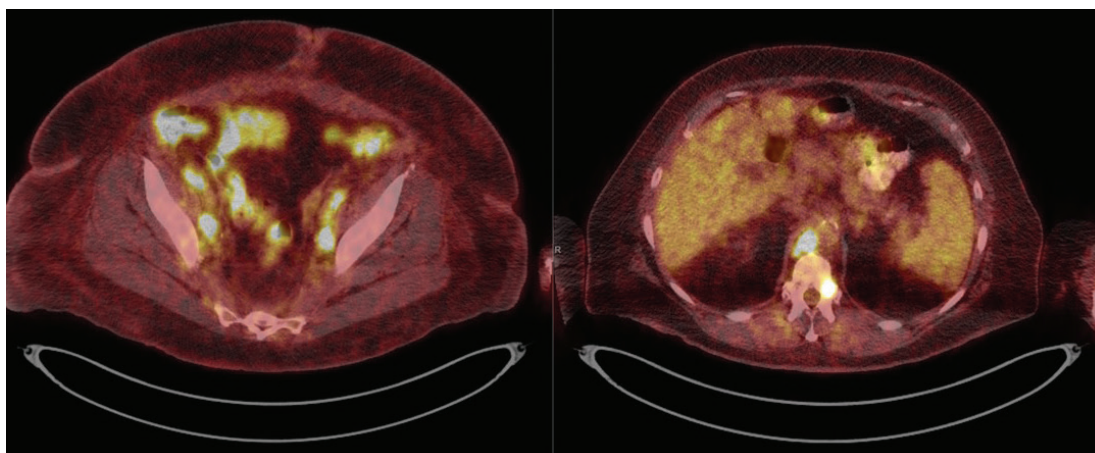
PET/CT scan shows multiple FDG avid bilateral iliac chain and pelvic lymph nodes (left) and left T12 lamina (right).
